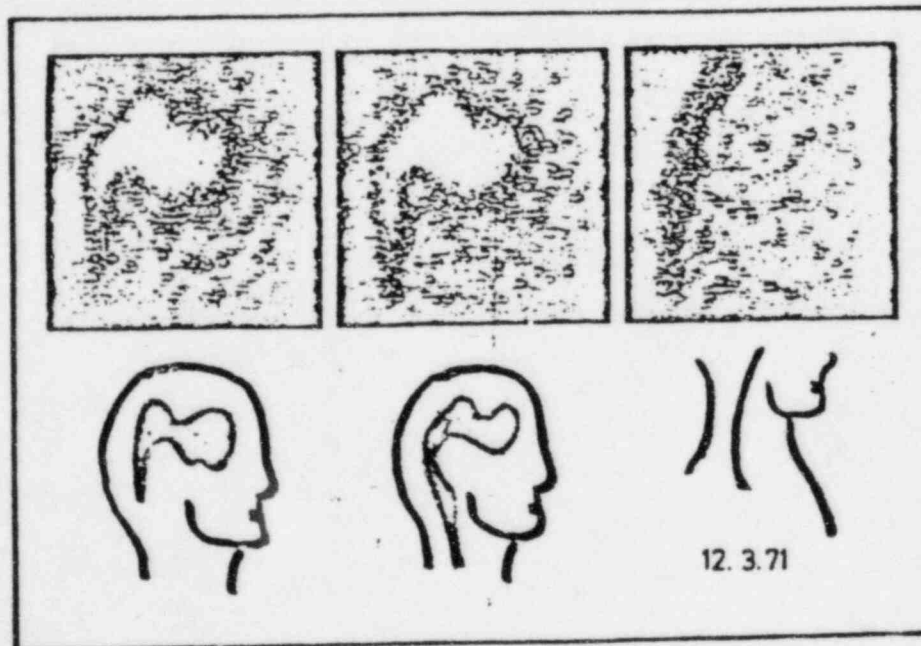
False negative: scintigraphically a normally functioning shunt. This sequence of scintiphotos shows the enlarged ventricular system with spontaneous flow in the proximal and distal catheters
